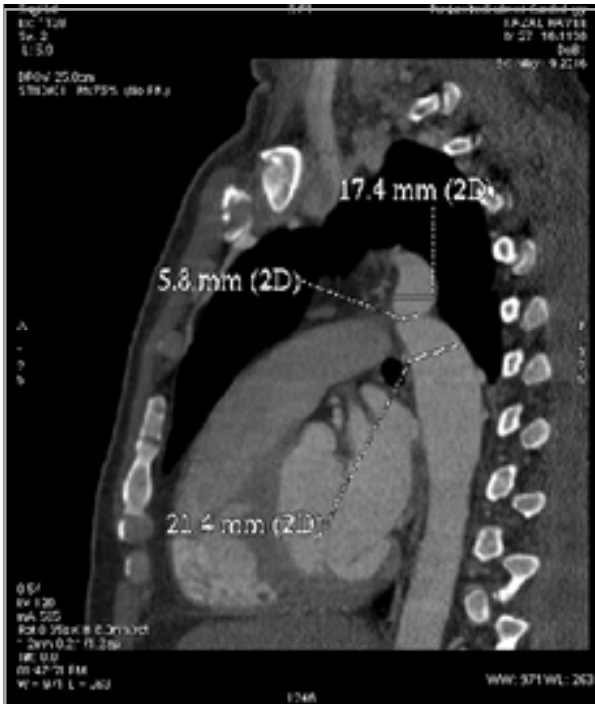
CT Angiogram showing coarctation of Aorta
